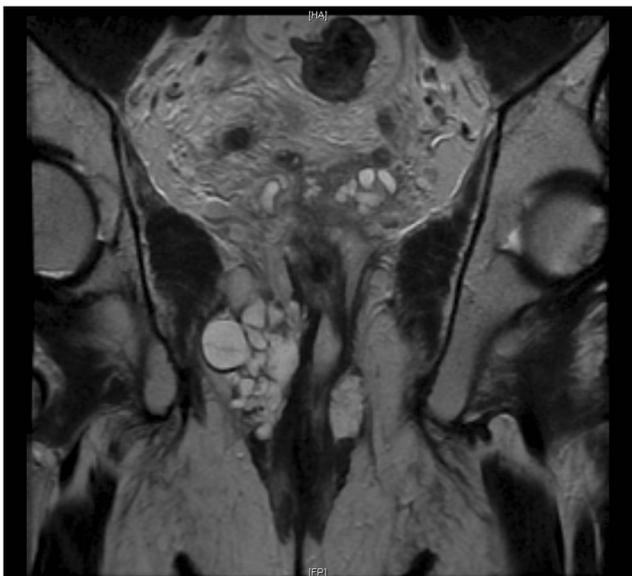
MRI T2-weighted axial image showing mucin reaching CRM in a case of rectal cancer post NACTRT
